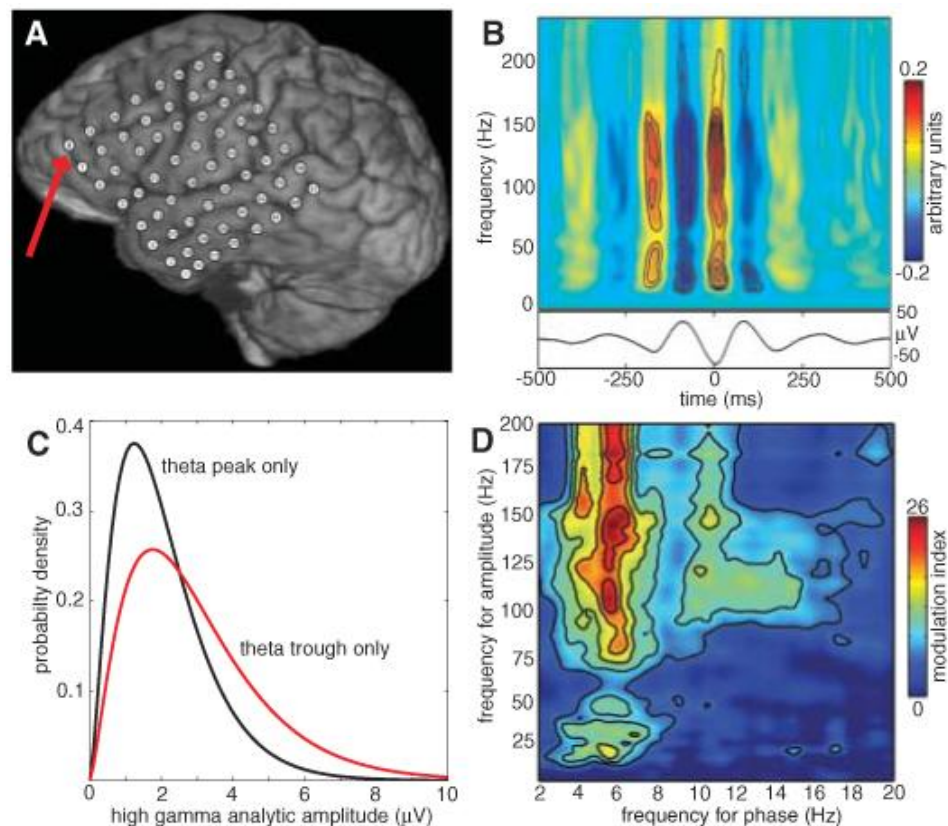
This figure shows that high gamma (80 to 150 Hz) power is modulated by theta (4 to 8Hz) phase. Plot A shows the MRI locations of the 64-channel ECoG grid (resting over frontal and temporal lobes). Plot B shows phase-locked modulation of power over the anterior portion of the middle frontal gyrus. Plot C shows the best-fit gamma distributions that occurred at the peak (black) trough (red) in radians of the theta waveform shown in plot B. Plot D is a modulation index as a function of analytic amplitude (5 to 200 Hz) and analytic phase (2 to 20 Hz) for the same electrode. (Canolty et al., 2006)
